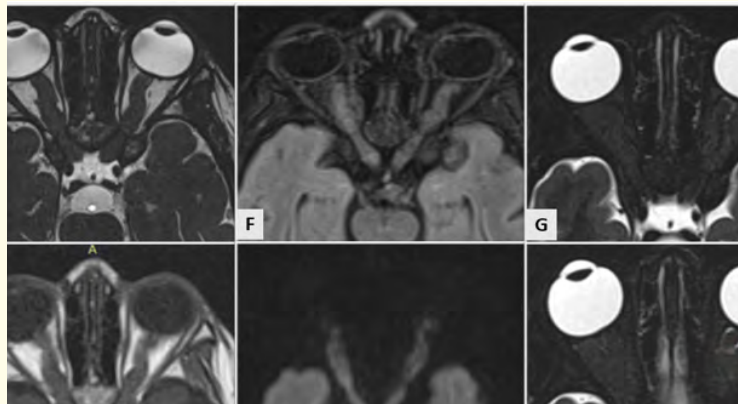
Non injected orbital sequences. Axial T2-weighted (E) and FLAIR (F) images show an iso intensity from the swollen optic nerves and a T1 hypo intensity (H) and STIR (G) weighting, intraconal fat is preserved with a homogeneous hypersignal (H), no diffusion hypersignal (I) and the red arrow points to the enlargement of the nerve sheath.
